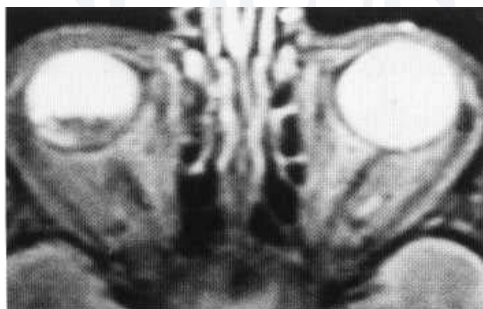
Dislocated lens. Axial T_2 -weighted MR image demonstrates dislocated right lens dependently within the vitreous chamber. Dislocation is also seen on axial non-contrast CT.
